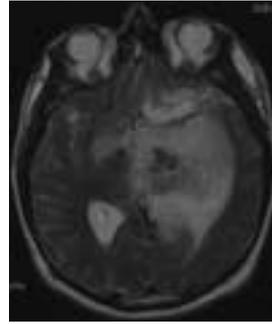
T2-weighted MRI obtained after surgery, showing a postoperative defect in the left temporal region. There is persistent oedema within the hemisphere, encroaching upon surrounding structures and causing progressive hydrocephalus.
